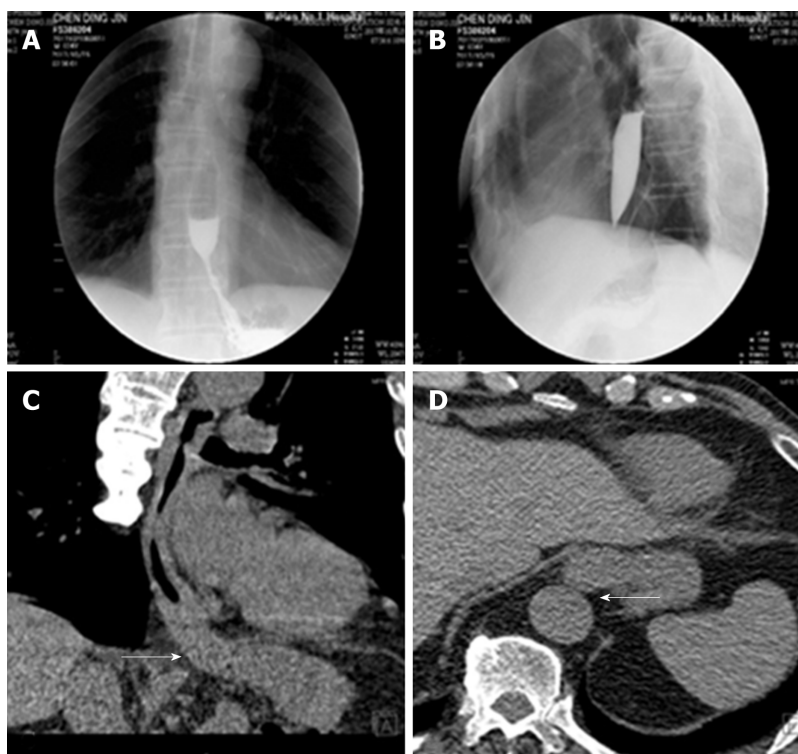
X-ray and thoracic computed tomography imaging of the patient. A and B: A barium meal X-ray revealed poor relaxation of the distal sphincter, dilatation of middle esophageal and stenosis of lower esophagus, weakened esophageal peristalsis, and ultimately stricture of the esophageal lumen with a beak-like appearance; C and D: Thoracic computed tomography imaging revealed thickening of the esophageal wall and antrum stricture (arrows), with a regular mucosal pattern.
